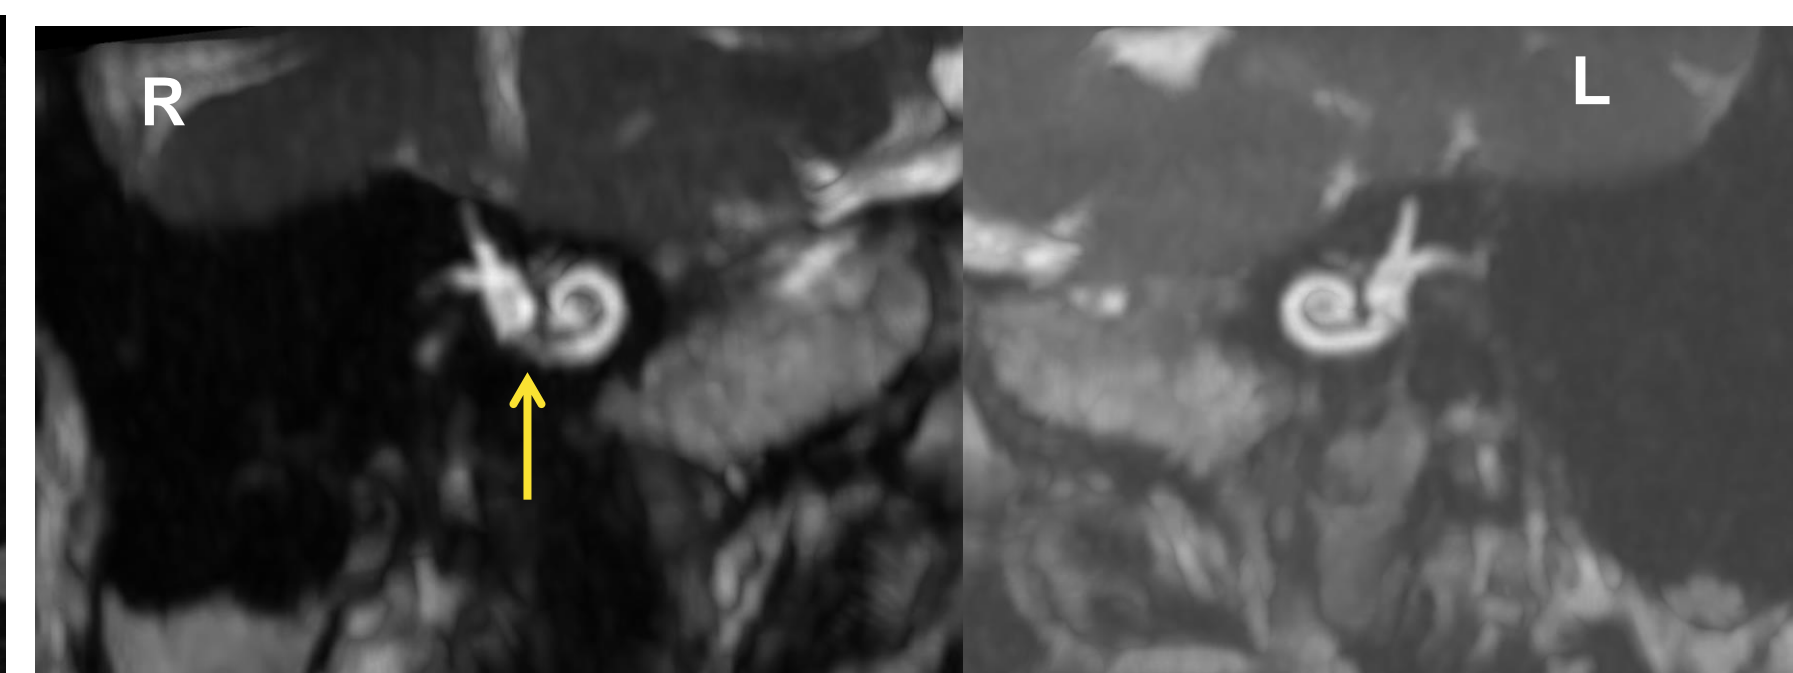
Oblique sagittal MRI in T2WI sequence with MIP reconstruction : Extinction of the T2 hyperintensity of the basal turn of the cochlea and the lateral semicircular canal on the right ear (yellow arrow)
